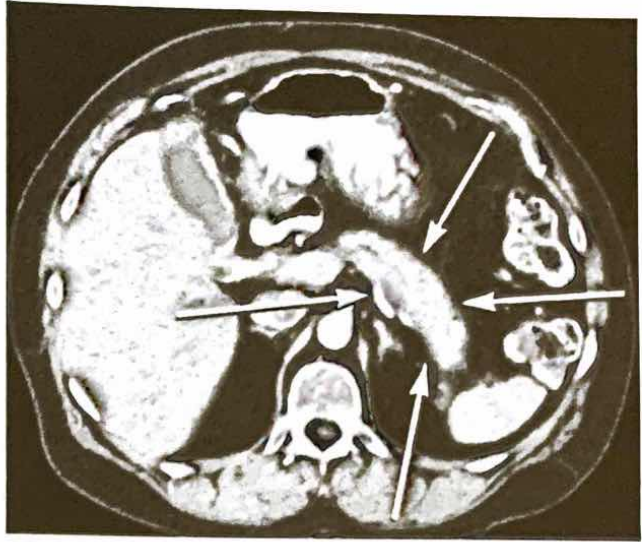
CT scan showing the homogeneous, hypodense “sausage-shaped” swelling (arrows) seen in autoimmune pancreatitis. The pancreatic duct is not dilated.
